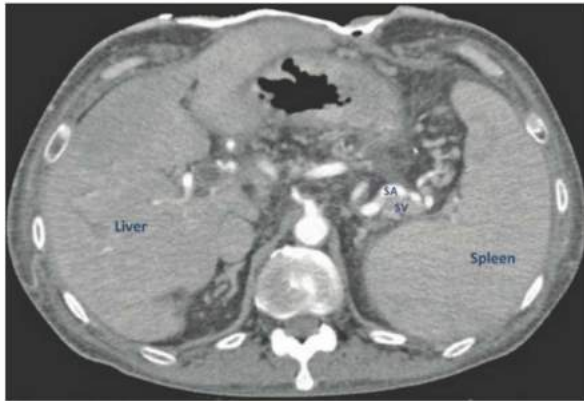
• CT image demonstrating splenomegaly. The volume of the spleen approaches that of the liver. SA, splenic artery; SV, splenic vein.
